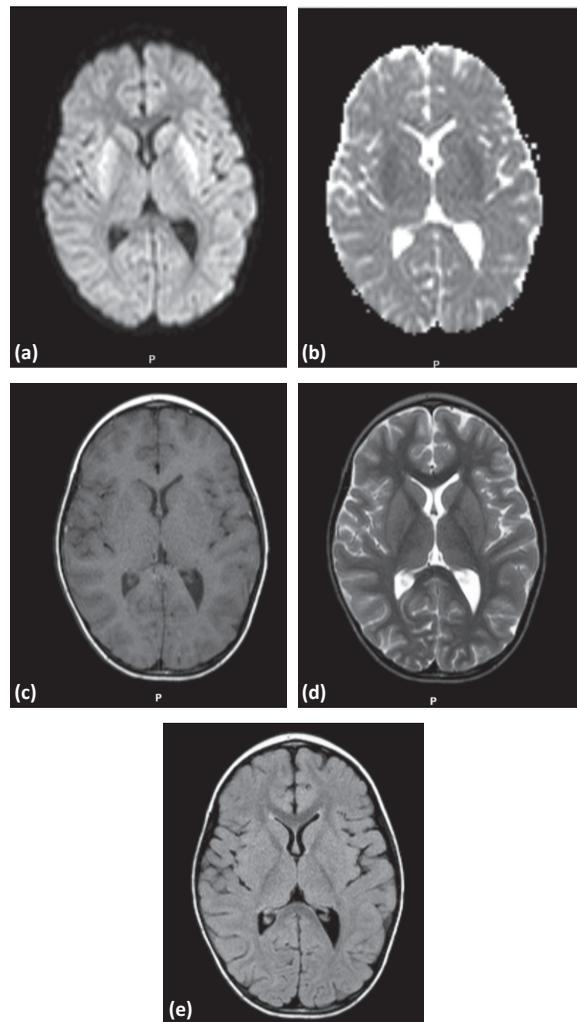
(a) Restricted diffusion of bilateral putamen as high signal on DW isotropic image and (b) low signal on ADC map (c) Normal conventional MRI findings, T₁ weighted axial images, (d) Normal T₂ weighted axial images, (e) Normal FLAIR-weighted images
